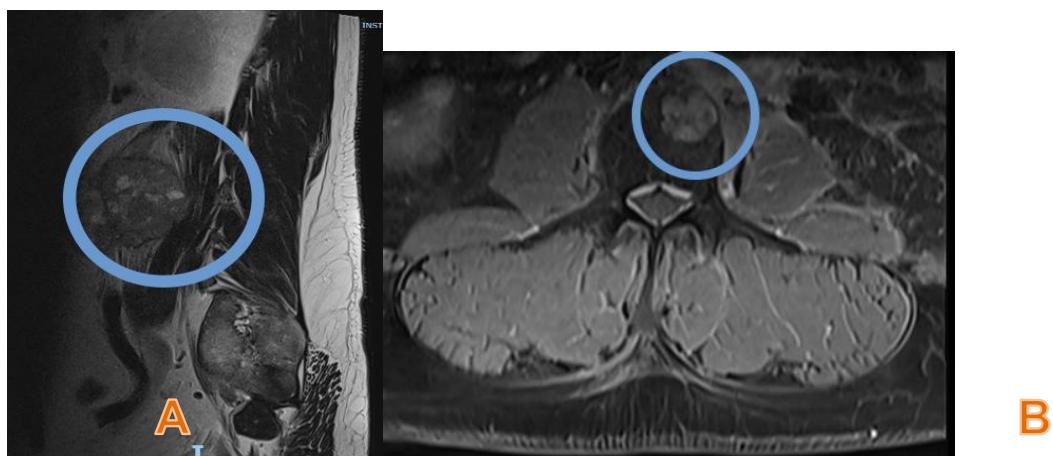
Initial contrast-enhanced lumbar MRI. A. Sagittal view: Tumor lesion with myxoid or cystic changes of lesser intensity in relation to the heterogeneous component. Displacement of intestinal loops anteriorly and close contact with paravertebral muscles. B. Axial view: Rounded, lobulated mass with heterogeneous signal; occupation of the neural foramen is observed, extending into the spinal canal and displacing the nerve root. In close contact with the edge of the vertebral pedicle.
